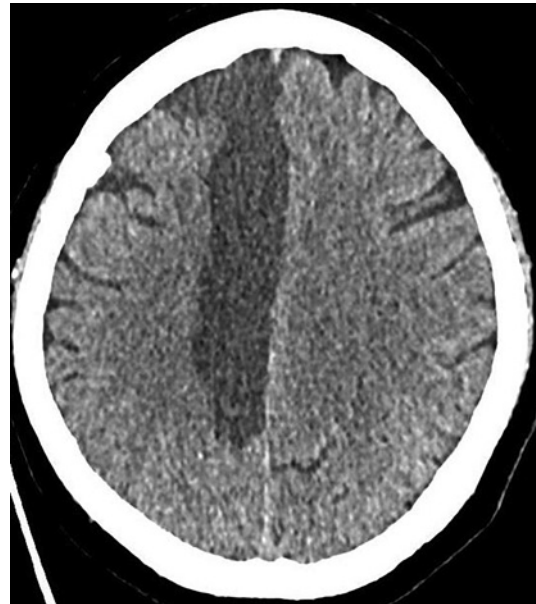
A native CT scan of the brain on day six showed a hypodensity indicating the infarction in the territory of the right ACA.
